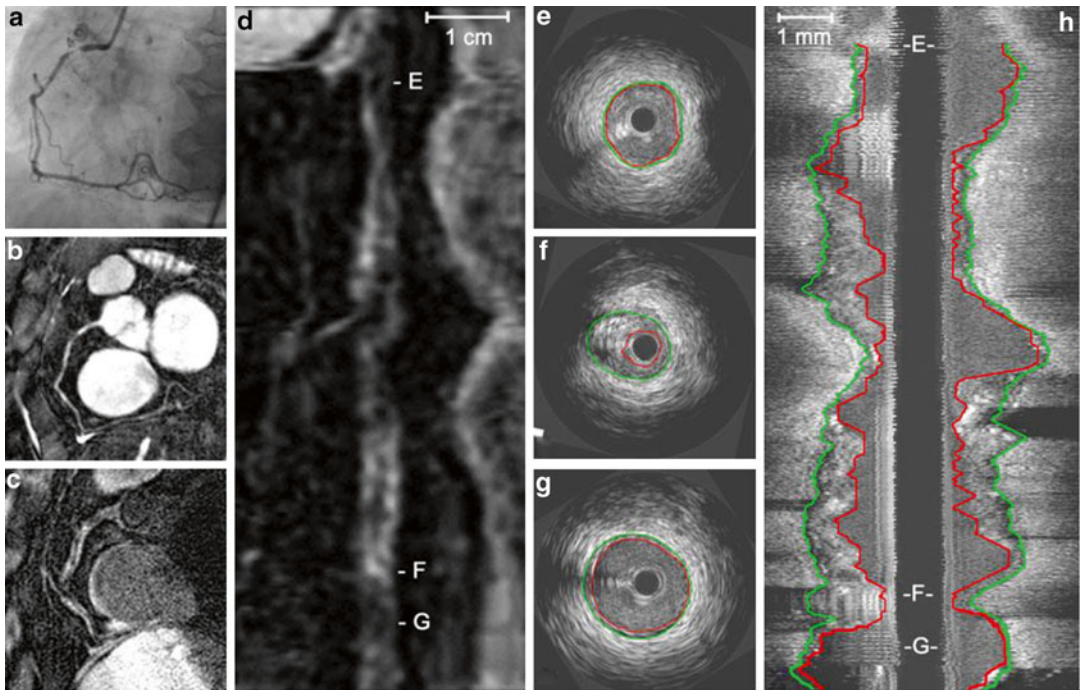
A 61-year-old female patient with stable angina. X-ray angiography (a) and coronary MRA (b) demonstrate high-grade stenosis in the proximal RCA. (c) Corresponding MR vessel wall image demonstrate several areas with vessel wall thickening and high signal intensity. (e) (Distal RCA), (f) (diseased area) and (g) (proximal RCA) are cross-sectional IVUS images and refer to the corresponding areas as shown on stretched
